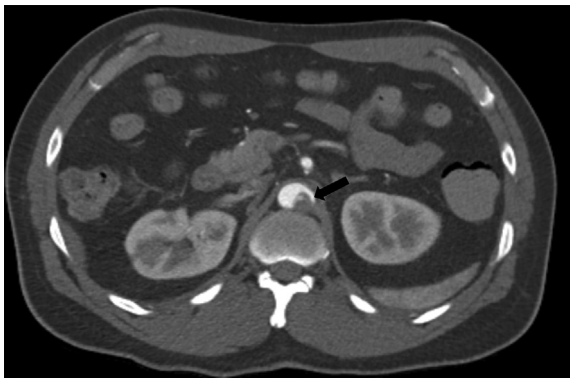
CT angiogram: Irregular mural thrombus seen in distal abdominal aorta resulting in moderate luminal narrowing (Black arrow).
